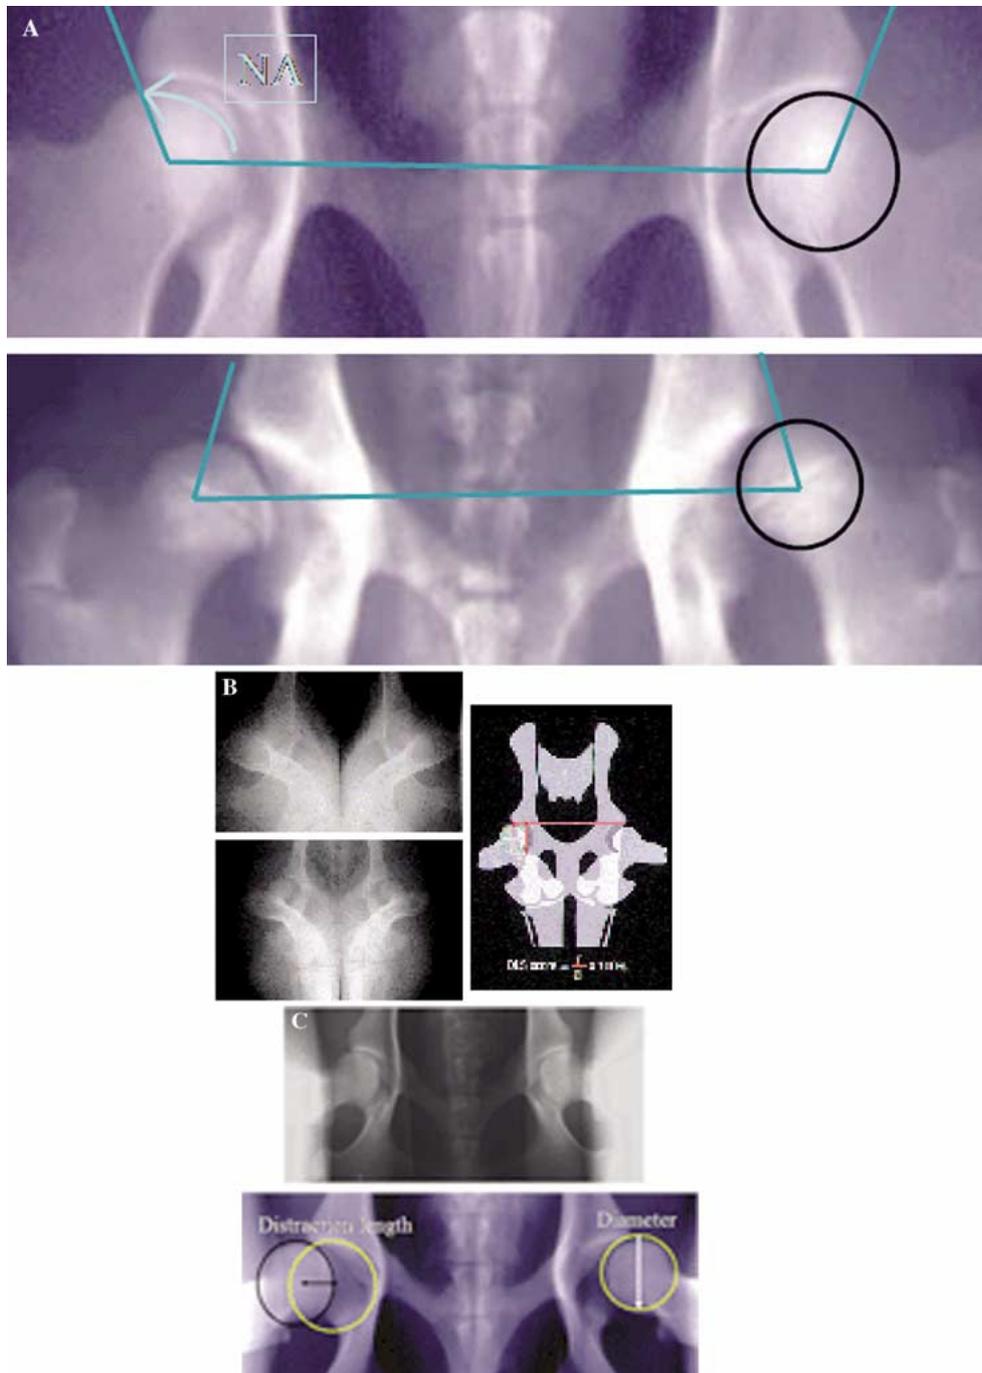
Images of radiographs (unaffected, top of each panel; dysplastic, bottom of each panel) of the extended-hip method (top) from which a score of hip conformation is derived which ranges from 1 (excellent) to the 7 (poorest) hip conformation. A. The Norberg angle is measured from this radiograph by extending a line connecting the geometric centers of each femoral head to the cranio (proximal) dorsal (posterior) acetabulum and measuring this included angle (Olsson 1961). B. The dorsolateral subluxation score is measured on this radiographic image (Farese et al. 1998) and is equivalent to the percent of femoral head covered by the acetabulum. The distance of the femoral head is within the acetabulum is expressed as a percentage of the femoral head diameter. C. The distraction index is measured on the distraction view as the maximum lateral passive hip laxity (Smith 1997). The distance between the geometric centers of the femoral head and acetabulum is divided by the diameter of the femoral head.
